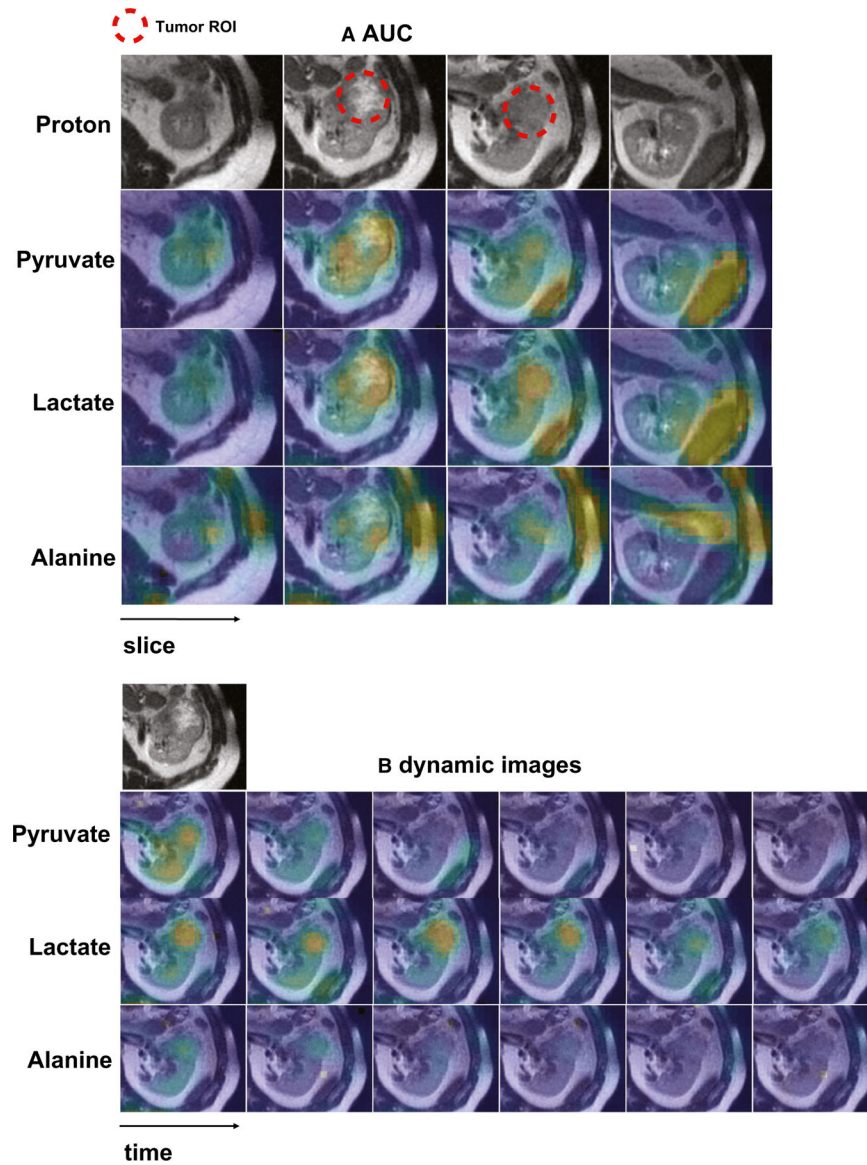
Representative hyperpolarized ^{13}C pyruvate magnetic resonance images are shown from a man aged 41 years who had 5.8-cm, grade 4 renal cell carcinoma. (A) Area under the curve (AUC) and (B) dynamic images acquired every 4 seconds show a left kidney tumor with increased pyruvate, lactate, and alanine signals compared with adjacent normal parenchyma. The AUC images also show intratumoral metabolic heterogeneity. In the AUC images, the signal-to-noise-ratios of the tumor are 119 for pyruvate, 18 for lactate, and 5.2 for alanine. ROI indicates region of interest.
